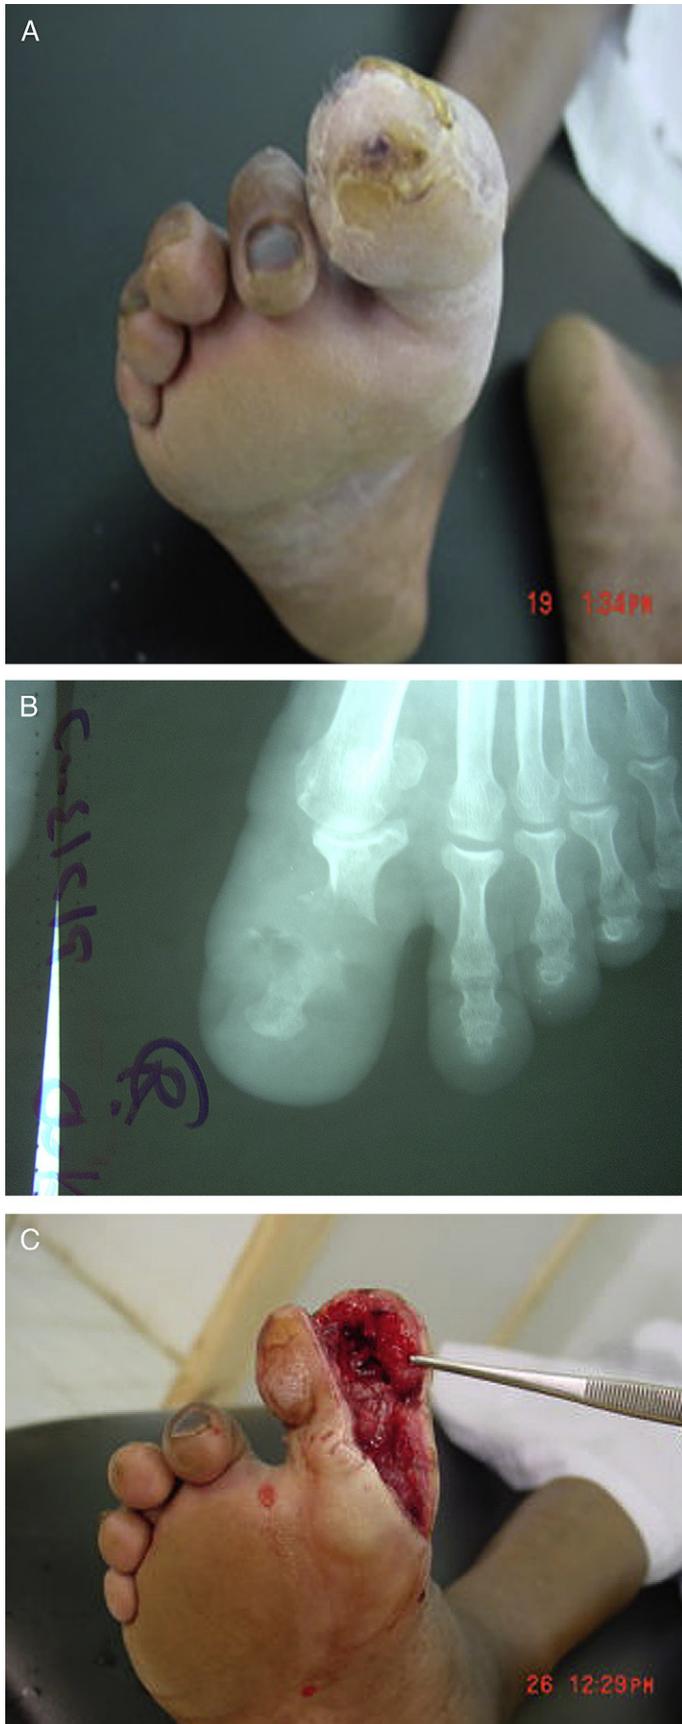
Osteomyelitis of the hallux, (A) clinical and (B) radiographic appearance. (C) Surgical excision of the infected and necrotic soft tissues and bone.
